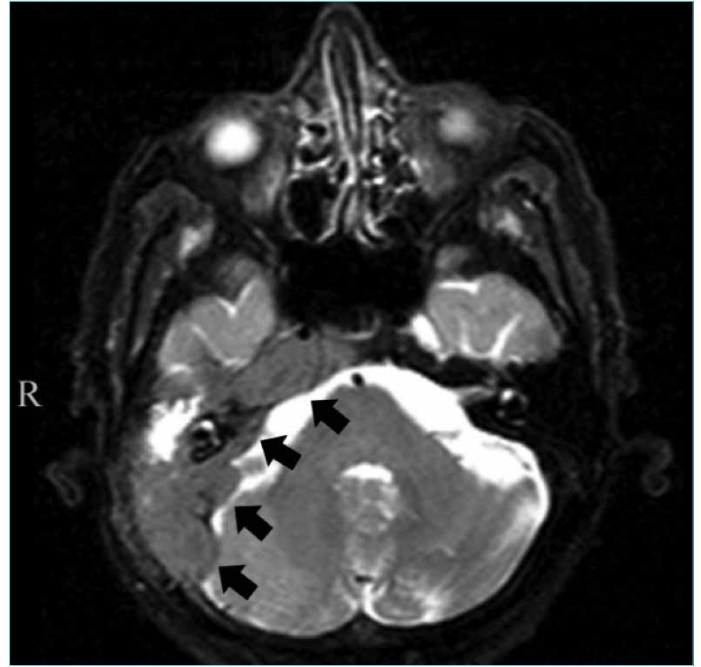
Axial T2 fat-suppressed MRI showing the extent of the metastatic mass (black arrows)
